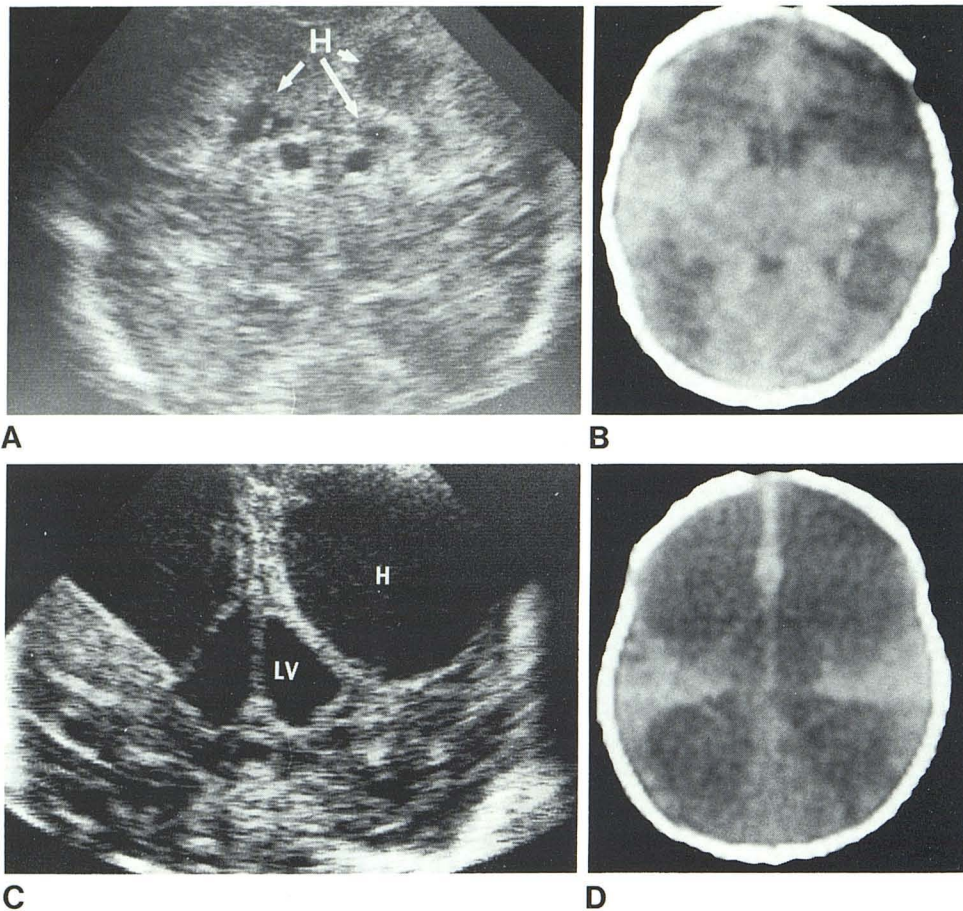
Case 2. A, Sonogram, coronal view, 13 days of age. Slightly prominent midline gyral markings. Parenchyma shows diffuse heterogeneity of echoes with bilateral periventricular hypoechoic areas (H). B, CT scan, 14 days of age. Bifrontal and biparietooccipital encephalomalacia with normal ventricles. C, Sonogram, coronal view, 29 days of age. Persistent parenchymal heterogenous echogenicity. Marked increase in size of frontal and parietal hypoechoic areas (H) with rim echogenicity and fewer internal echoes. Increase in lateral ventricular (LV) dilatation. D, CT scan, 30 days of age. Marked bilateral frontal and parietooccipital secondary porencephaly and ventriculomegaly.
